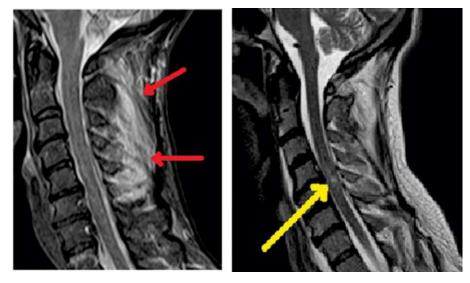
An MRI can be used to identify soft tissue abnormalities not apparent on radiography. On the left is an MRI showing interspinous ligament injury (red arrows). On the right, the yellow arrow points to a non-hemorrhagic contusion in the spinal cord. (Courtesy of BMC Musculoskelet Disordv.17; 2016PMC4957861)
